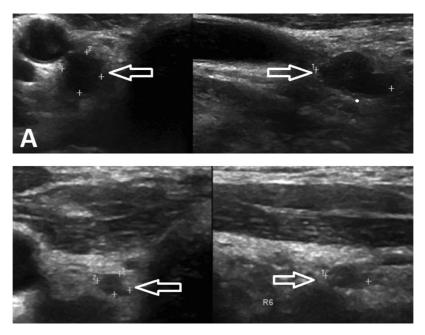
Ultrasound images show metastatic lymph nodes. (A) The first lymph node (arrows). (B) The second lymph node (arrows).
